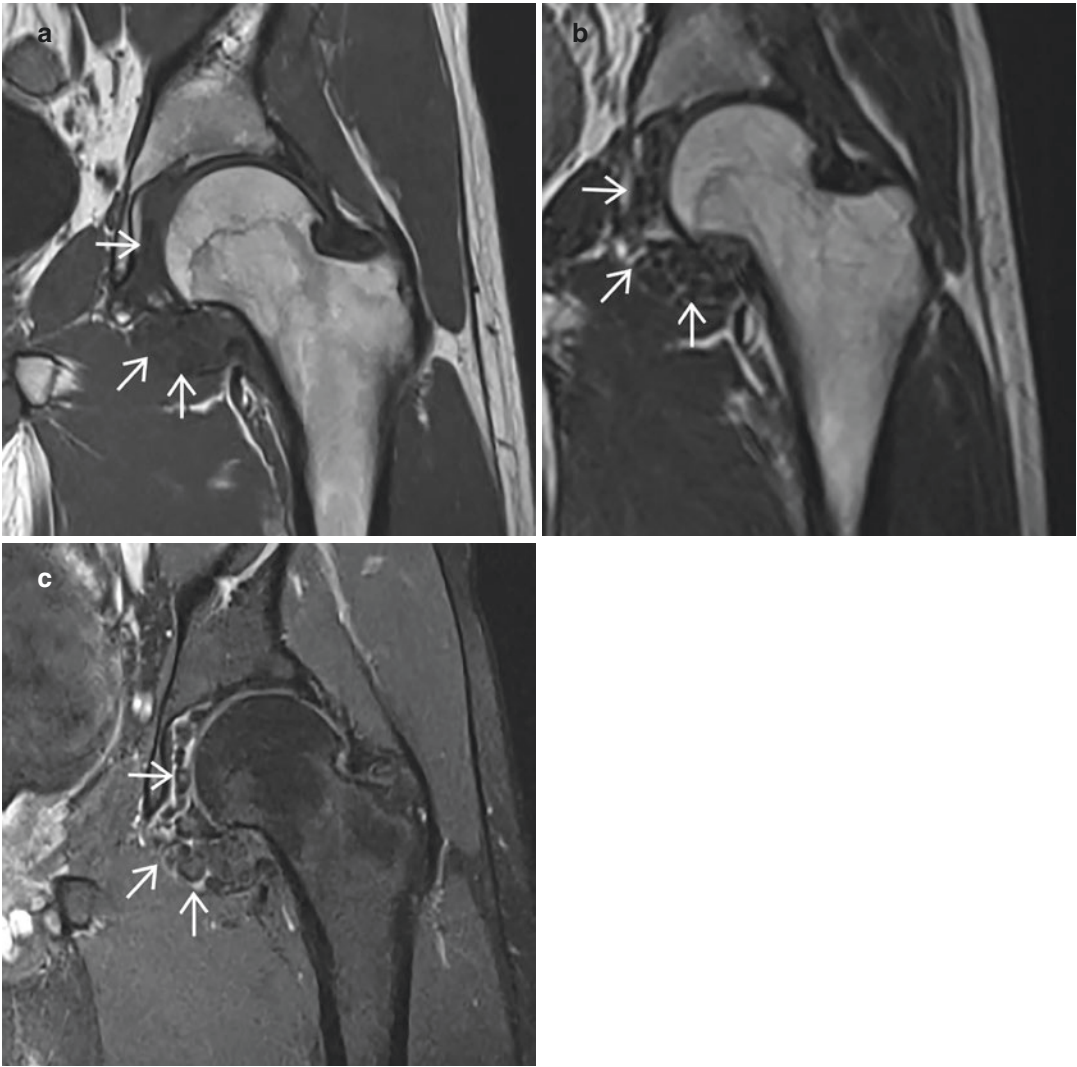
Synovial chondromatosis. Coronal (a) T1-weighted, (b) T2-weighted, and (c) contrast-enhanced fat-suppressed T1-weighted MR images of the left hip
